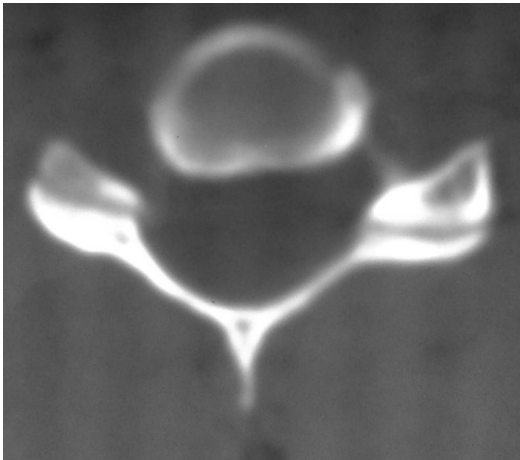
Preoperative CT scan showing anomalous “non-bifid” spinous process of other subaxial vertebrae [C5 in this image].
